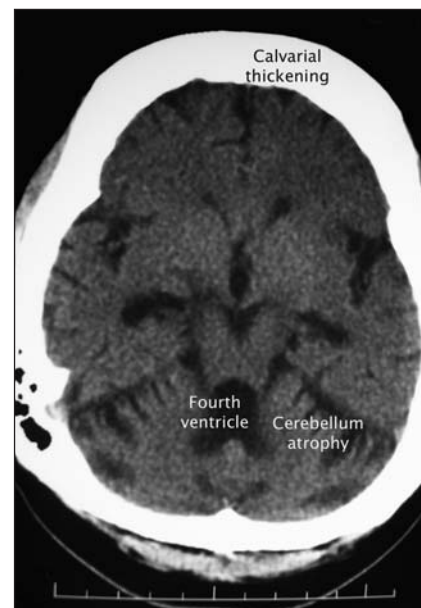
Axial plain CT scan after prolonged anticonvulsant therapy showing cerebellar atrophy with secondary dilation of the fourth ventricle and marked (symmetrical) hyperostosis of the skull.
